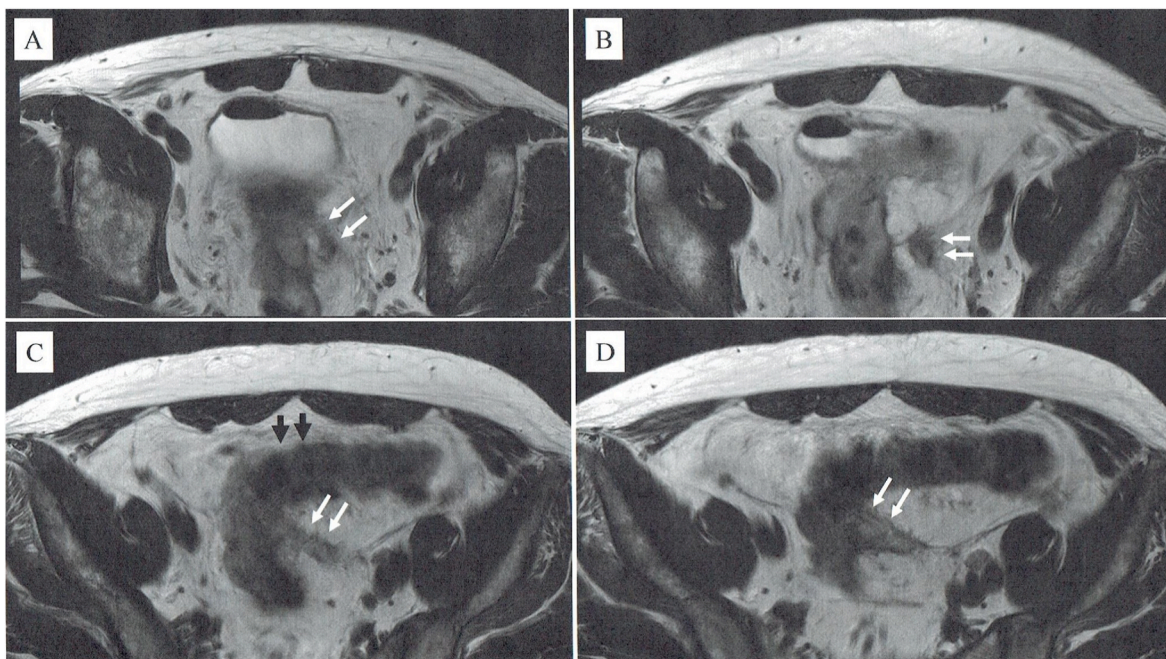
MRI findings of the coloseminal fistula. A: The fistula is connected to the seminal vesicle (white arrows). B: The fistula near the seminal vesicle (white arrows). C: The fistula is connected to the sigmoid colon (white arrows). Black arrows point the sigmoid colon. D: The fistula close to the sigmoid colon (white arrows).
